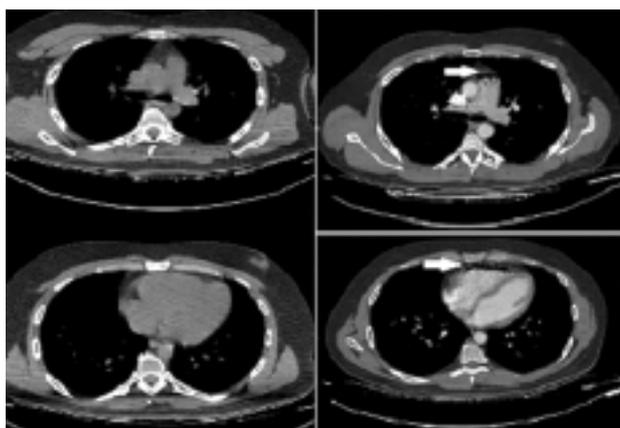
There was air in right cardiac spaces (pulmonary artery (C) and right ventricle (D) on contrast thorax computed tomography but not in non-contrast one (A, B).
